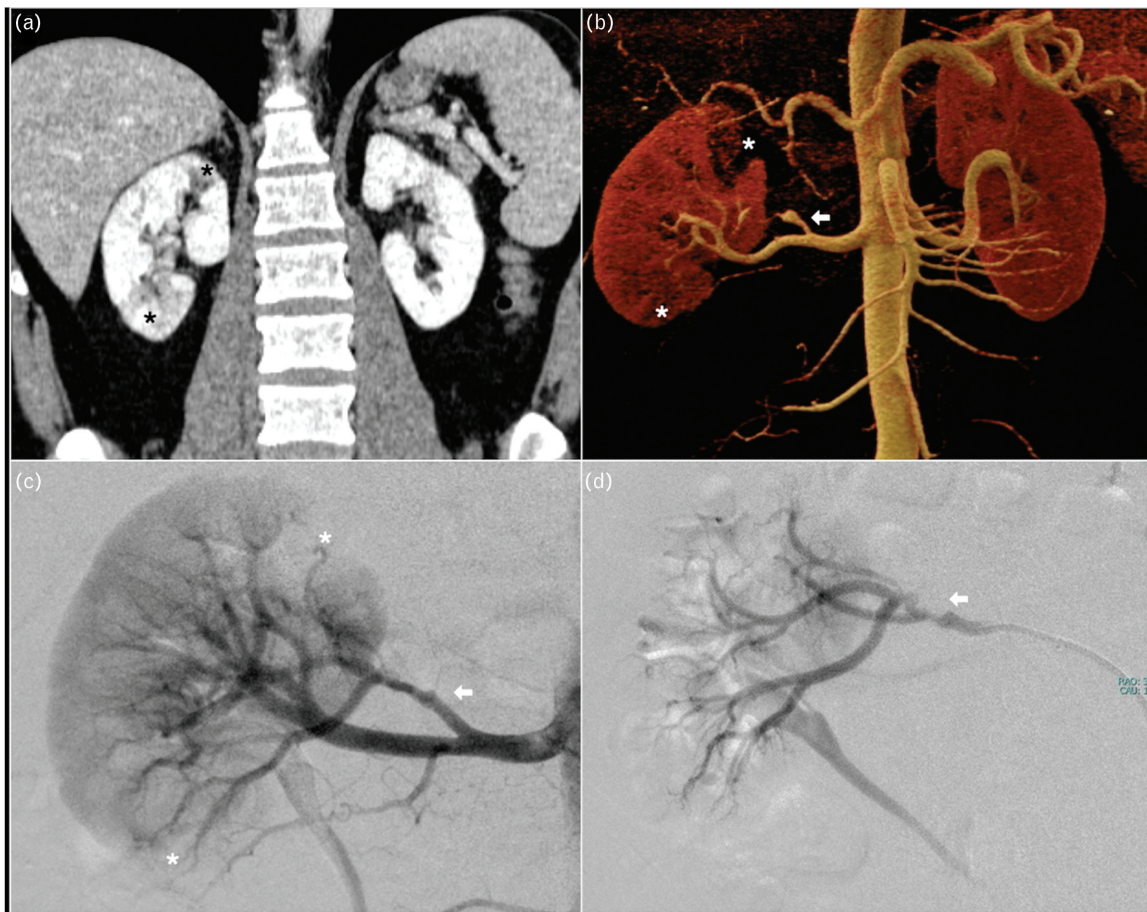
(a) Coronal CT scan in the arterial phase shows lower density at the upper and lower poles of the right kidney (asterisks in a). CT 3D VR reconstruction shows an aberrant branch for anterior segments of the kidney with ectasia followed by tight stenosis (arrows in b). The upper and lower poles of the right kidney are hypo-perfused (asterisks in b). Selective DSA of the right renal artery confirms the renal aberrant branch with irregular profiles for the anterior segments of the kidney (arrows in c) and hypo-perfusion at the upper and lower poles (asterisks in c). Super-selective DSA of the aberrant branch highlights fibrodysplastic stenosis (arrow in d). DSA, digital subtraction angiography.
